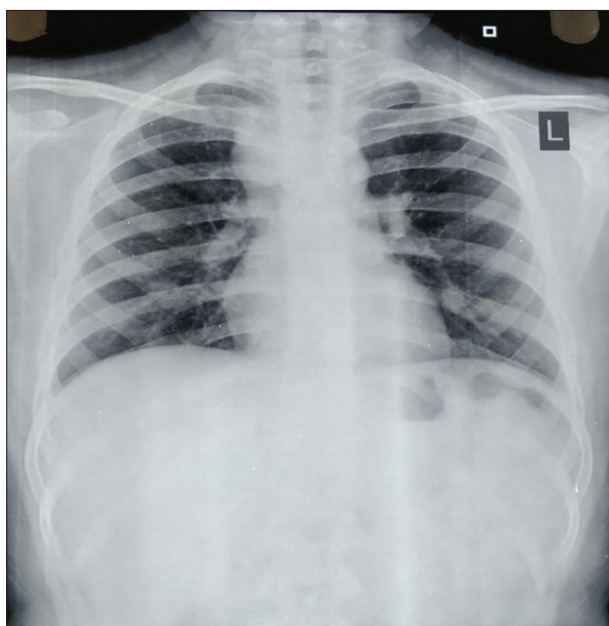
Chest X-ray PA view.
